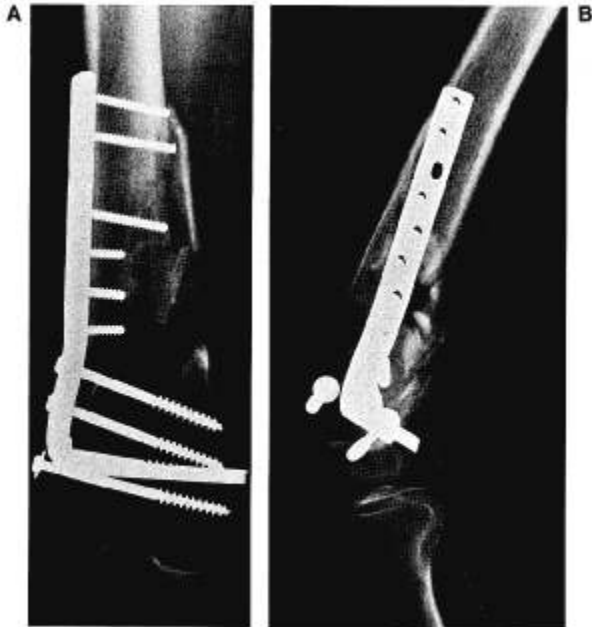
(A) Anteroposterior (AP) and (B) lateral radiographs of the initial fixation of an intraarticular T-shaped fracture with distal shaft comminution. A fixed-angle blade plate was placed in varus, resulting in valgus malalignment of the distal femur. The distal fragment is in extension in relationship to the femoral shaft.
